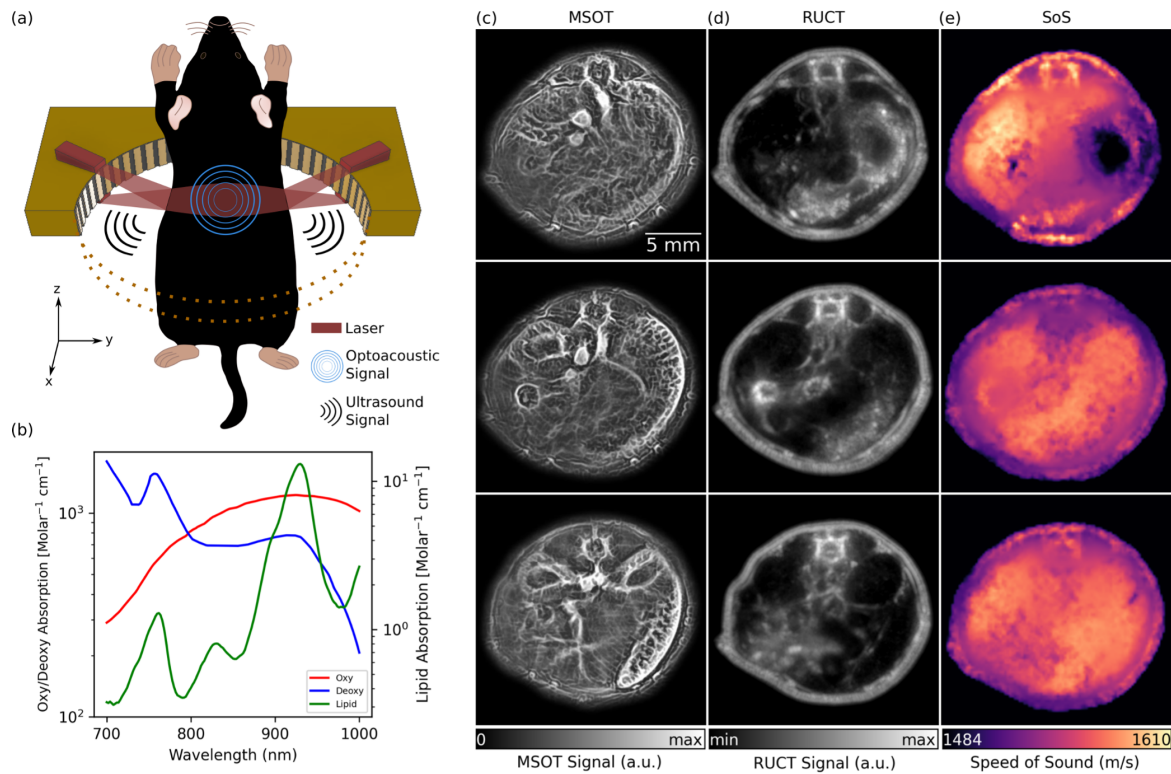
TROPUS imaging. (A) Lay-out of the imaging set-up combining three modalities, namely MSOT, RUCT and SoS imaging. Only half of the ring array is shown for better visualization. (B) Absorption spectrum of Hb, HbO<sub>2</sub> and lipid in 700 nm and 1000 nm wavelength range. (C) Exemplary MSOT images from different cross sections recorded at 1064 nm excitation wavelength. (D) The corresponding cross sections reconstructed with the RUCT modality. (E) The corresponding cross sections showing the SoS maps reconstructed with TUCT modality. Hb: deoxy-hemoglobin; HbO<sub>2</sub>: oxy-hemoglobin, MSOT: multispectral optoacoustic tomography; RUCT: reflection ultrasound computed tomography; SoS: speed of sound; TROPUS: transmission-reflection optoacoustic ultrasound; TUCT: transmission ultrasound computed tomography.
